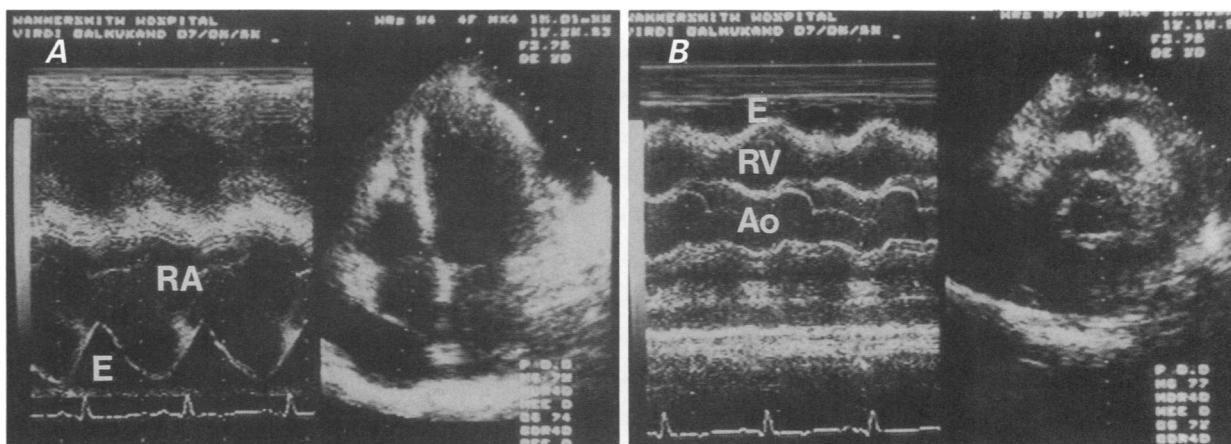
M-mode and cross-sectional echocardiograms revealing A) right atrial collapse during early systole in the apical 4-chamber view and B) right ventricular collapse during early diastole in the parasternal short-axis view. In the M-mode images, note the presence of a moderate pericardial effusion.
